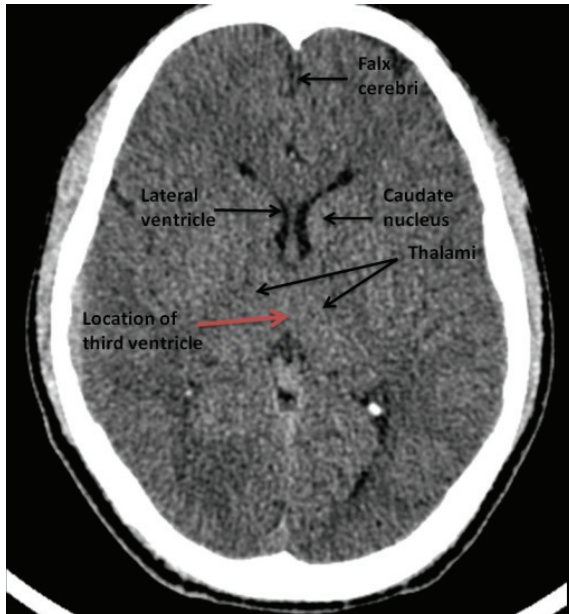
Non Contrast CT Axial Image at the level of interventricular foramen showing trace third ventricle
